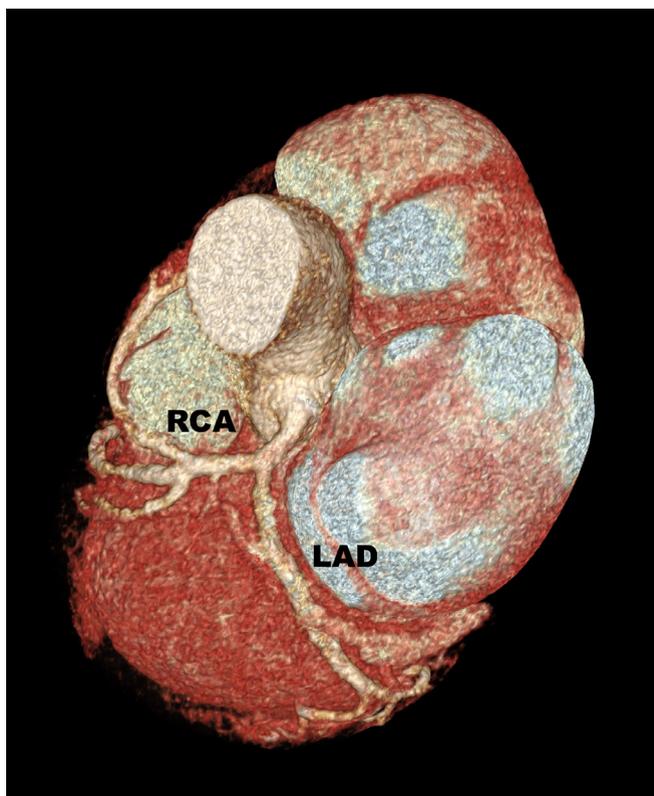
Single coronary artery (SCA) type Lipton type L2-A. Coronary computed tomography angiography, volume-rendered reconstruction shows a SCA originating from the left sinus of Valsalva and dividing into the right coronary artery and left anterior descending artery. LAD = left anterior descending artery; LCx = left circumflex artery; RCA = right coronary artery.
